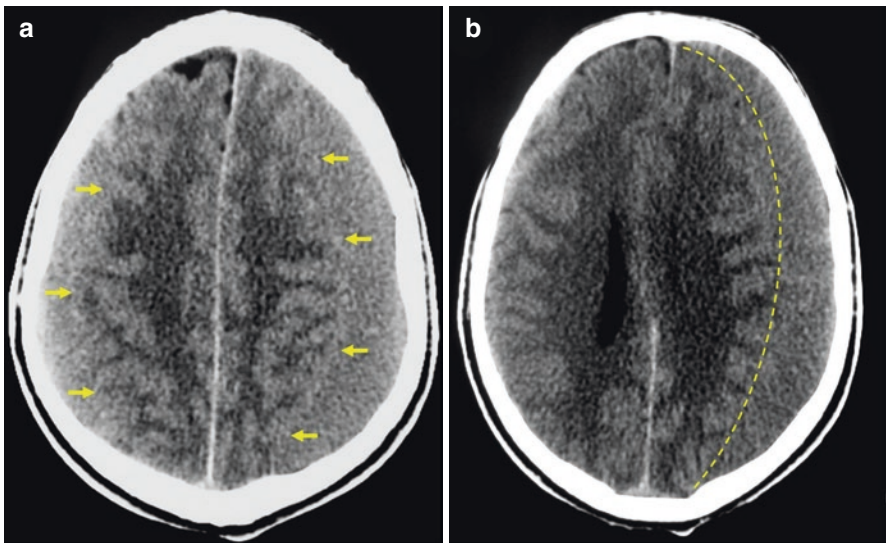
Axial non-enhanced CT-scan. Bilateral isodense CSDH hardly distinguished from the adjacent normal brain parenchyma (arrows) (a). Unilateral left isodense subdural hematoma: the internal limit is difficult to differentiate from the adjacent brain parenchyma (dotted line) (b)
